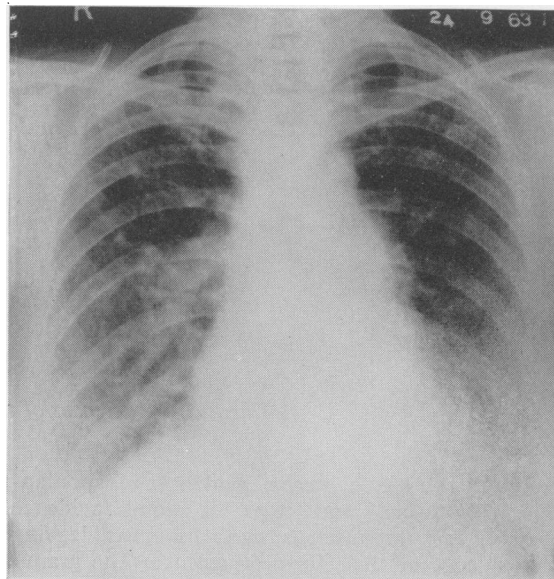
Radiograph of chest, 1963, showing widespread linear and finely mottled opacities in the lungs and enlargement of the heart shadow with prominence of the pulmonary conus.
